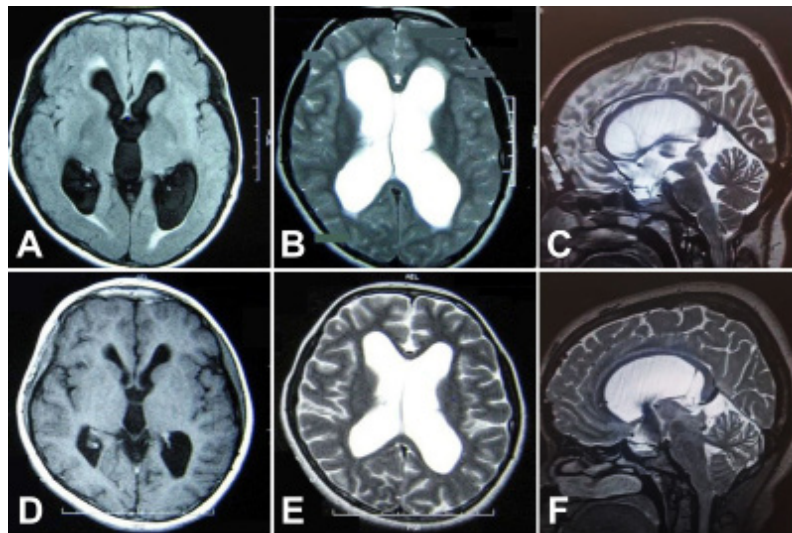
(A, B, C) Preoperative MRI (axial flair, axial T2-weighted image and saggital T2-weighted image) of a case of LIAS showing evident supratentorial ventriculomegaly with CSF permeation and cortical sulci effacement, associated with downward bulging of the third ventricle floor and CSF pathway obstruction at the aqueduct. (D, E, F) Postoperative MRI (axial T1-weighted image, axial T2-weighted image and saggital T2-weighted image) showing successful communication between the third ventricle and the prepontine cistern.
